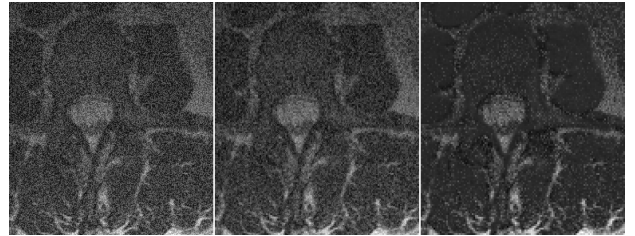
Processing of the spinal MR image number 3 presenting (a) the effect of threshold selection on the mean square error (MSE) value, (b) original image, (c) image with additional random noise, and (d) de-noised image using the optimal threshold value
